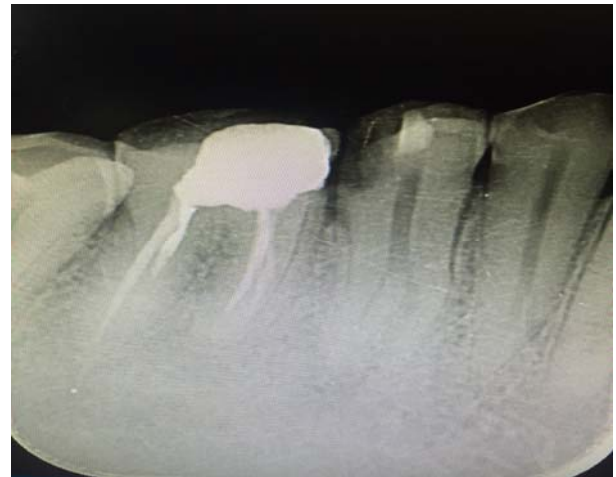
Pre-operative radiographic picture showing mid root bifurcation of the root with two separate canals
